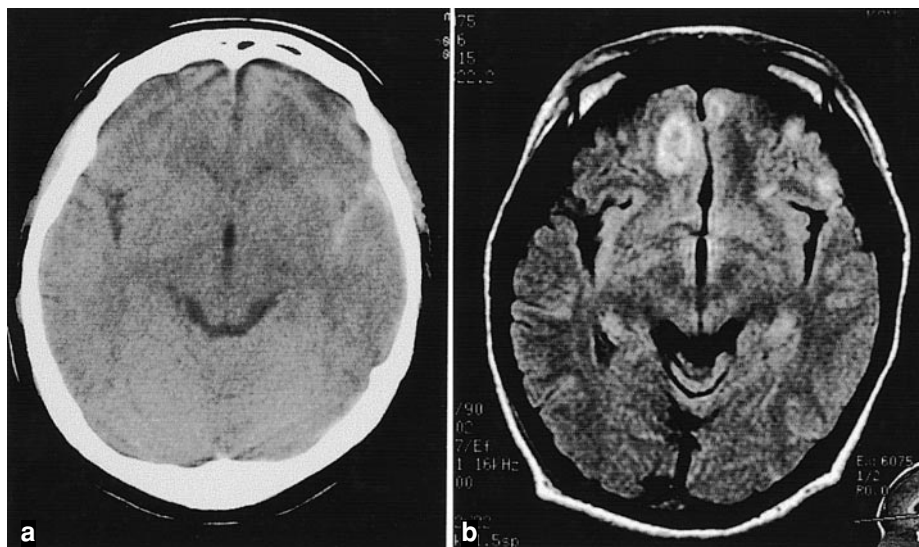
CT scan on admission showed subarachnoid hemorrhage, but showed no obvious brain contusion (a). However, MR imaging of Day 5 showed bifrontal contusion (b)
